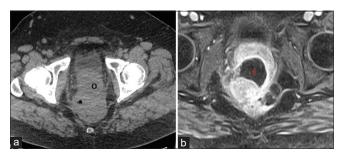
A 34-year-old male presenting with abdominal pain. (a) Axial pre-contrast computed tomography image shows an abscess that was not initially appreciated in this study (o). (b) Follow-up axial fat-saturated post-contrast T1-weighted magnetic resonance shows an abscess in the left pararectal space (*).
